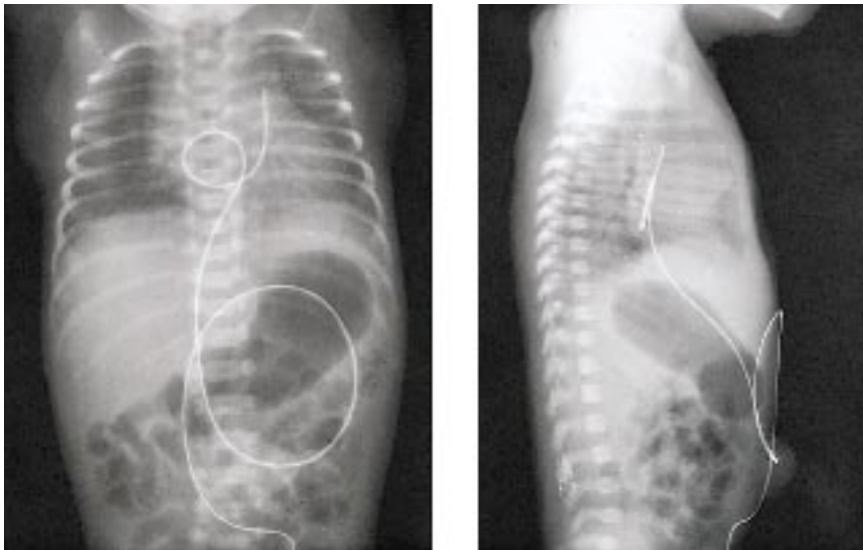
Anteroposterior and lateral radiographic views of an infant with an umbilical venous catheter placed in the left pulmonary artery. The previous figure and this figure stress the importance of checking placement of umbilical catheters following their insertion. When they are placed in such abnormal positions they should be withdrawn.
